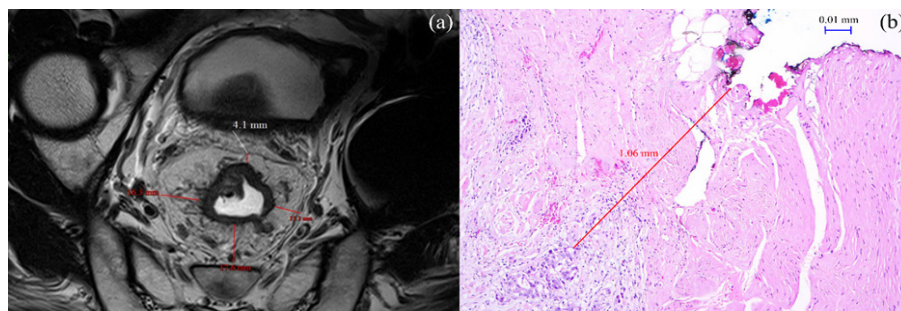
Radiologic and Pathologic Assessment of CRM. (a) MRI shows uninvolved mrCRM (4.1 mm). (b) Pathology indicated uninvolved pCRM (1.06 mm)
